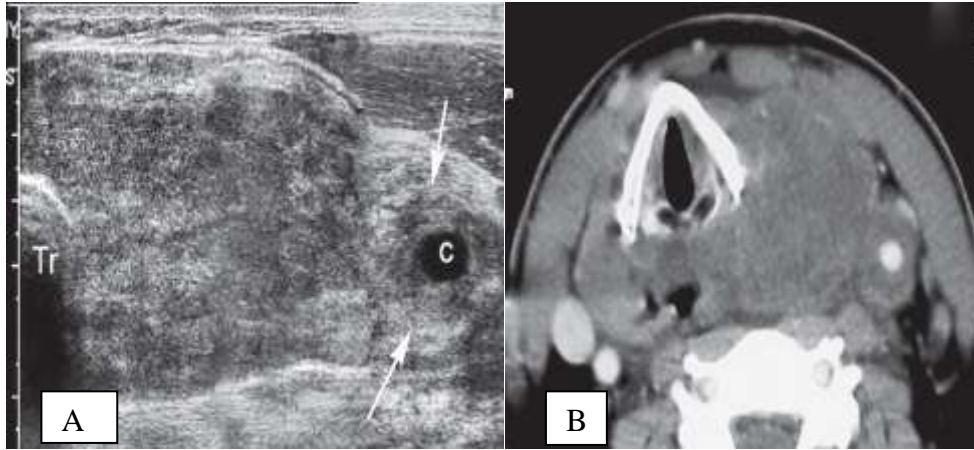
Lymphoma . *A, Transverse image of left lobe of the thyroid shows diffuse mass enlarging the lobe and extending into the soft tissues (arrows) surrounding the common carotid artery (c); Tr, tracheal air shadow. B, Contrast-enhanced CT scan shows a hypovascular mass in the left thyroid lobe and soft tissue encasement of the carotid artery.*
